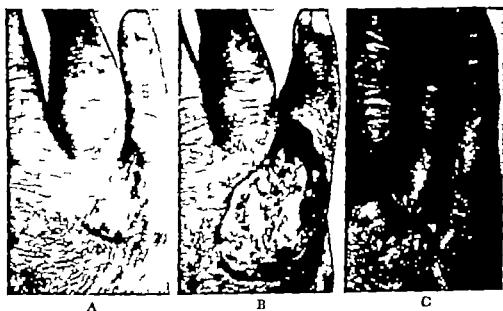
(A) Squamous cell carcinoma, grade 3 malignancy. The neoplasm had recurred after three courses of roentgen therapy. (B) Granulation tissue after chemosurgical excision. The exposed tendons soon became covered with granulation tissue and epithellum, their extensor function was retained. (C) Healed lesion. The central dark area is at the point where an adherent scale had been pared off with slight bleeding. There was no recurrence after six years.
